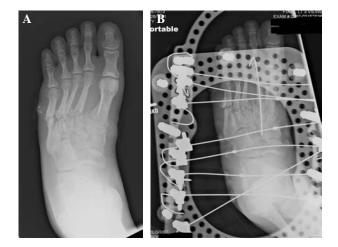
(A) Open comminuted tarsometatarsal joint fracture dislocation. (B) Radiograph after a closed reduction and percutaneous pinning as well as placement of a ring external smooth wire fixator.
